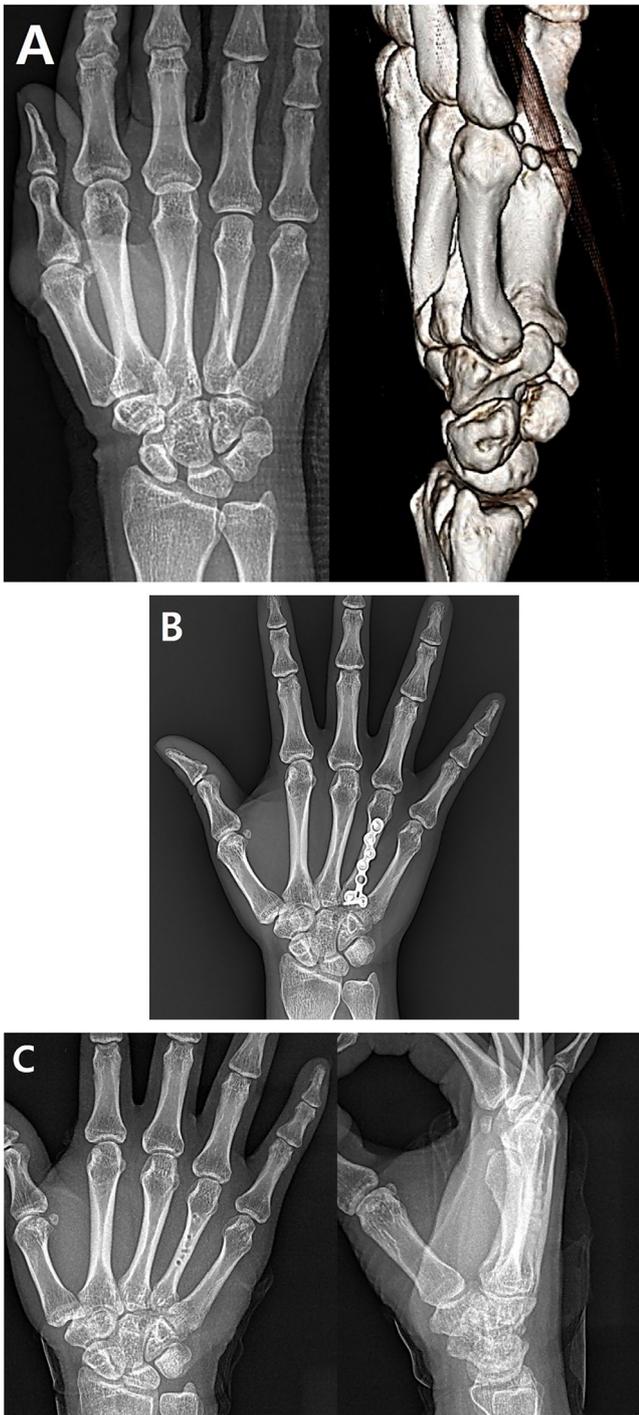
A 54-year-old female. (A) An oblique fracture at the fourth metacarpal bone. Dorsal angulation was 28° on a three-dimensional computed tomography scan. (B) Open reduction and internal fixation (ORIF) using a low-profile plate was performed. (C) About a 10° extension lag was present 10 months postoperatively with discomfort when contacting the hand dorsum. Thus, the plate was removed under a brachial plexus block. The final visual analog scale and Disabilities of the Arm, Shoulder, and Hand scores were 0 and 6.8, respectively, without any discomfort 30 months postoperatively.
